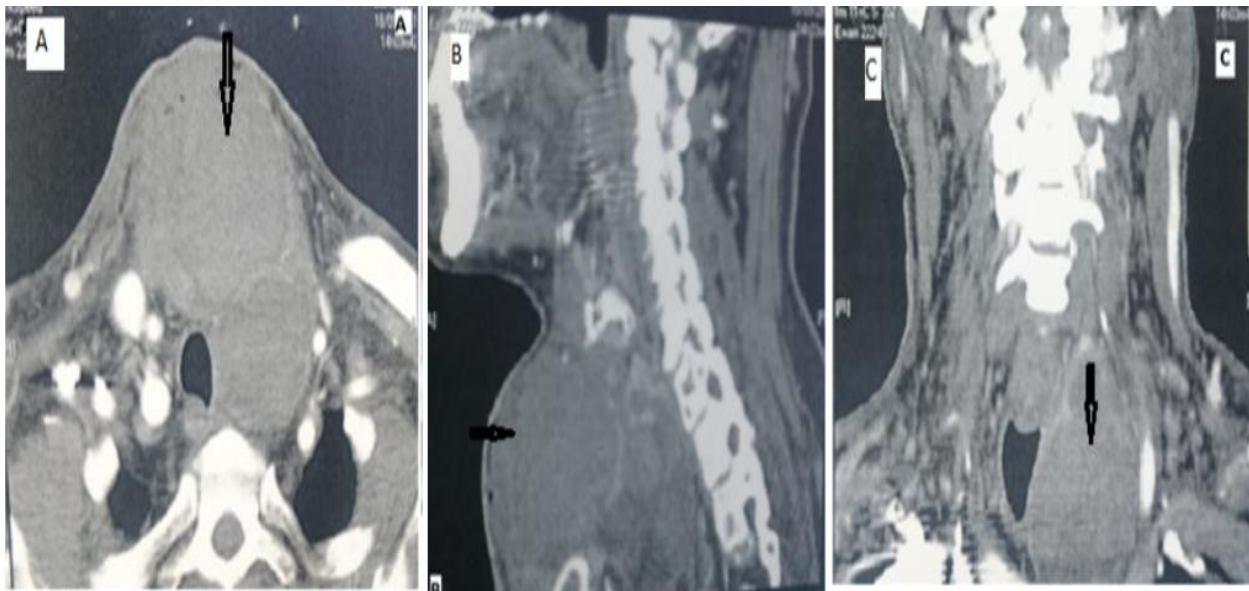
Computed tomography of cervico-thoracic hematoma occupying the thyroid compartment. A: axial section. B: sagittal section. C: coronal section.
